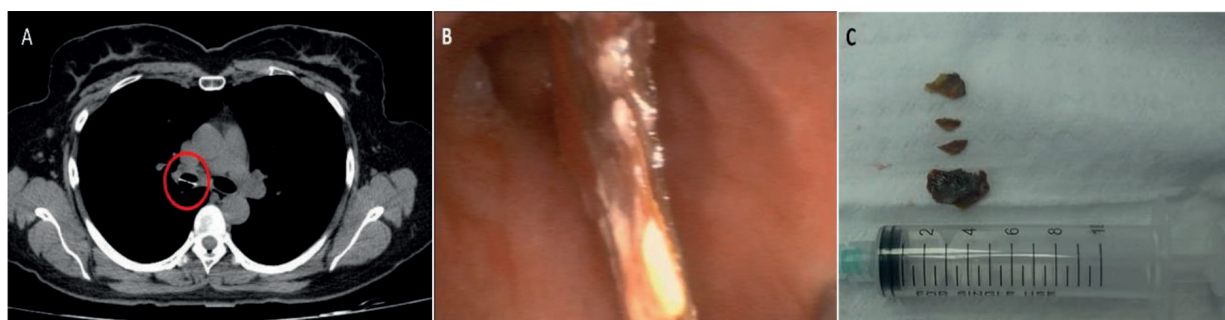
A. Chest computed tomography (axial section). Hyperdense image located in the right main bronchus. B. Endoscopic view showing a foreign body in the main bronchus causing partial obstruction of its lumen. C. Foreign body (fish bone) extracted with rigid bronchoscopy.
